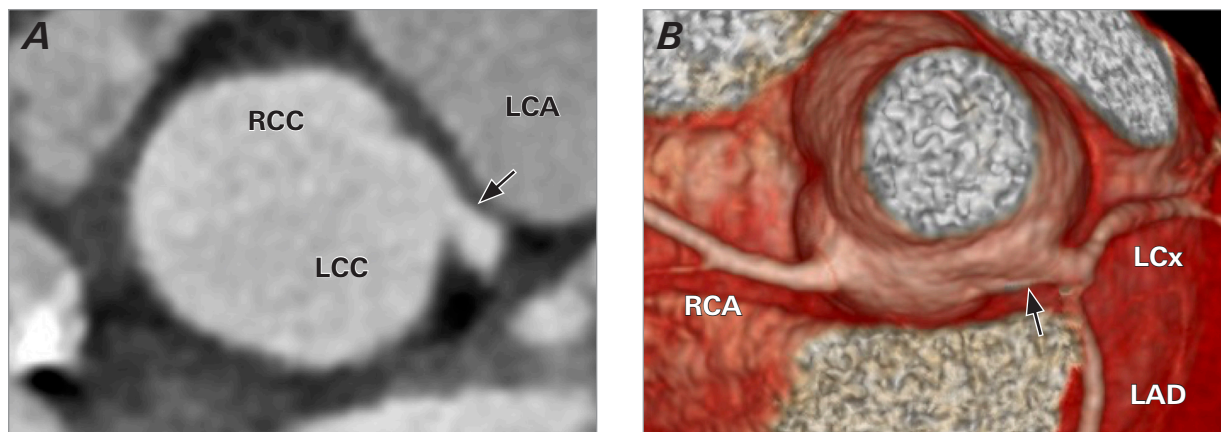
Findings of coronary computed tomography angiography in the patient after the unroofing operation. A) The origin of the LCA was corrected to the left sinus of Valsalva (arrow), and B) the orifice of the LCA had become a normal shape (arrow).
